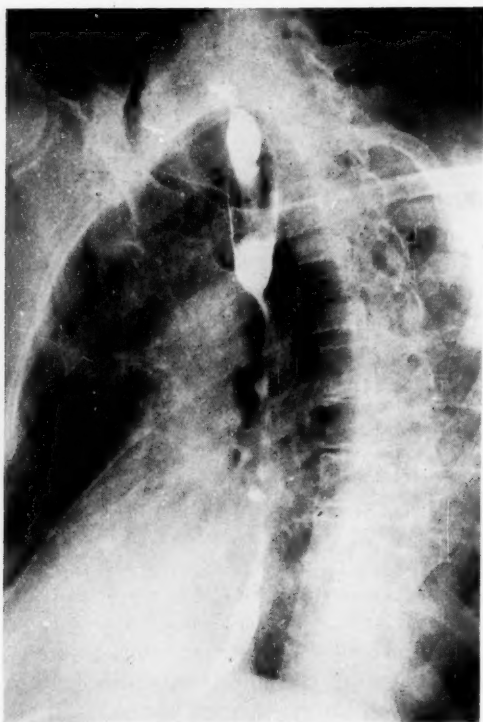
Case 1.—X-ray appearance showing multiple strictures of the esophagus beginning at the episternal notch.
